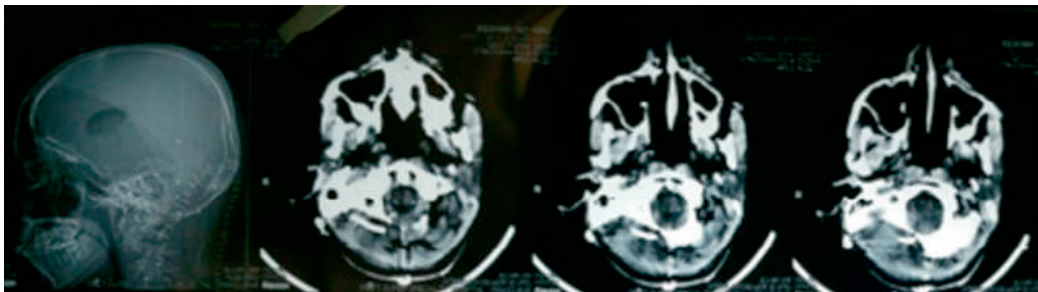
Post op CT showing clip in situ
